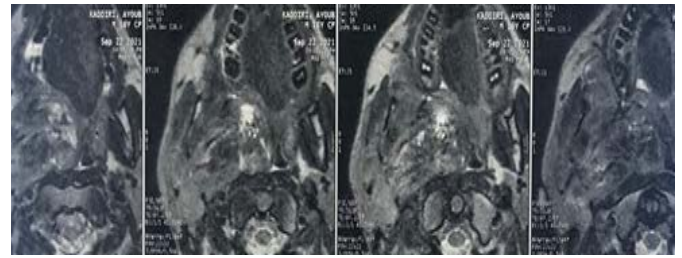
MRI on axial section showing the tumor that infiltrates the right parotid, the right parapharyngeal space and the nasopharynx, partially filling its lumen.
